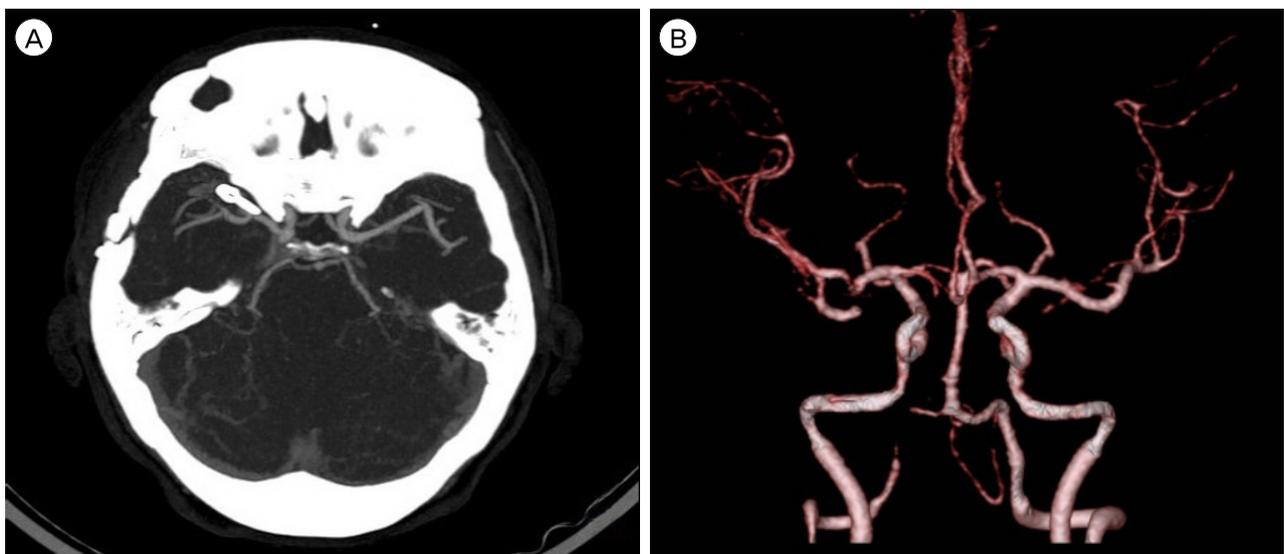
Follow-up computed tomography angiography 1-year after the operation. The clip is observed in the source image of the computed tomography angiography (A), and there was no evidence of the remnant aneurysm (A, B).
